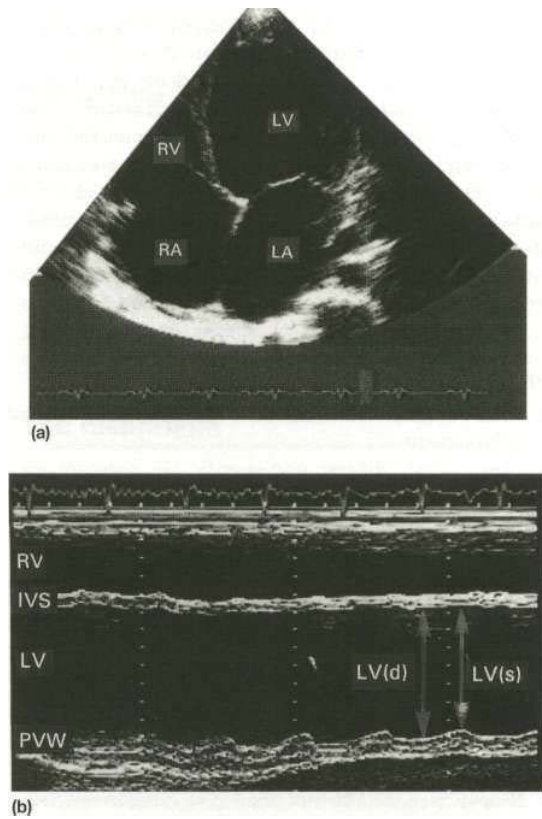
Dilated cardiomyopathy shown in two-dimensional (apical four-chamber view) and M-mode echocardiograms. The heart has a 'globular' appearance with all four chambers dilated. The extremely impaired left ventricular function can be appreciated from the M-mode recording. Compare the systolic shortening fraction with that of Figures 13.26 and 13.29. LA, left atrium; RA, right atrium; LV, left ventricle; LV(d) and LV(s), diastolic and systolic left ventricular dimensions; IVS, interventricular septum; PVW, posterior ventricular wall.
